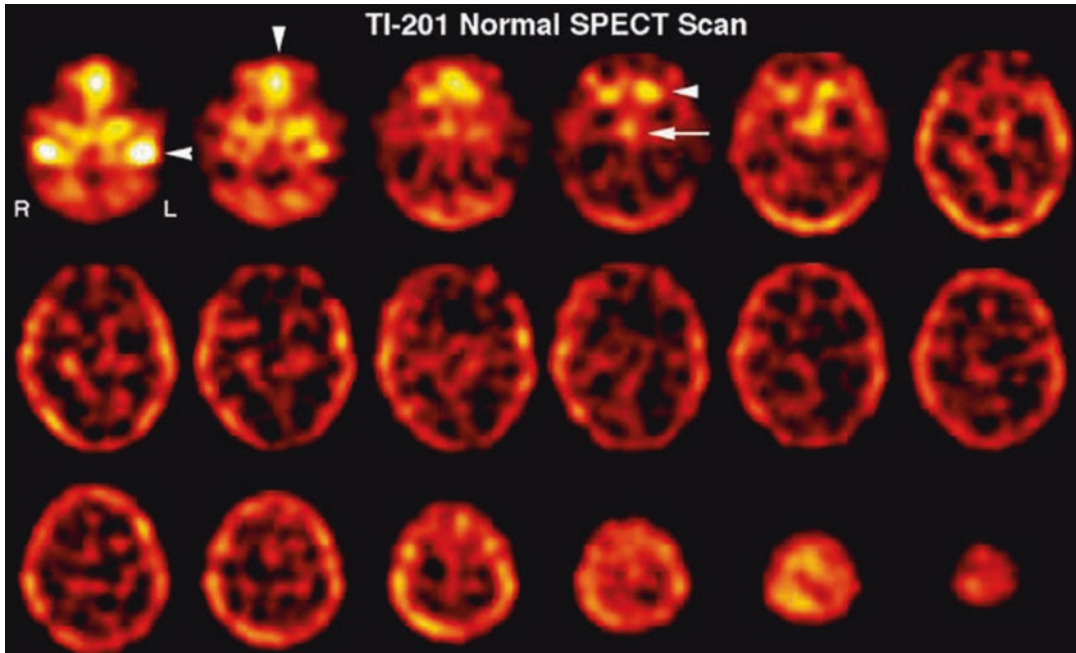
SPECT scan of ^{201}Tl in the normal brain. Uptake of ^{201}Tl in the normal brain is very low. It is important to note that there is significant uptake by some of the structures just inferior to the cranium, which can interfere with the positive detection of tumor in the inferior frontal
